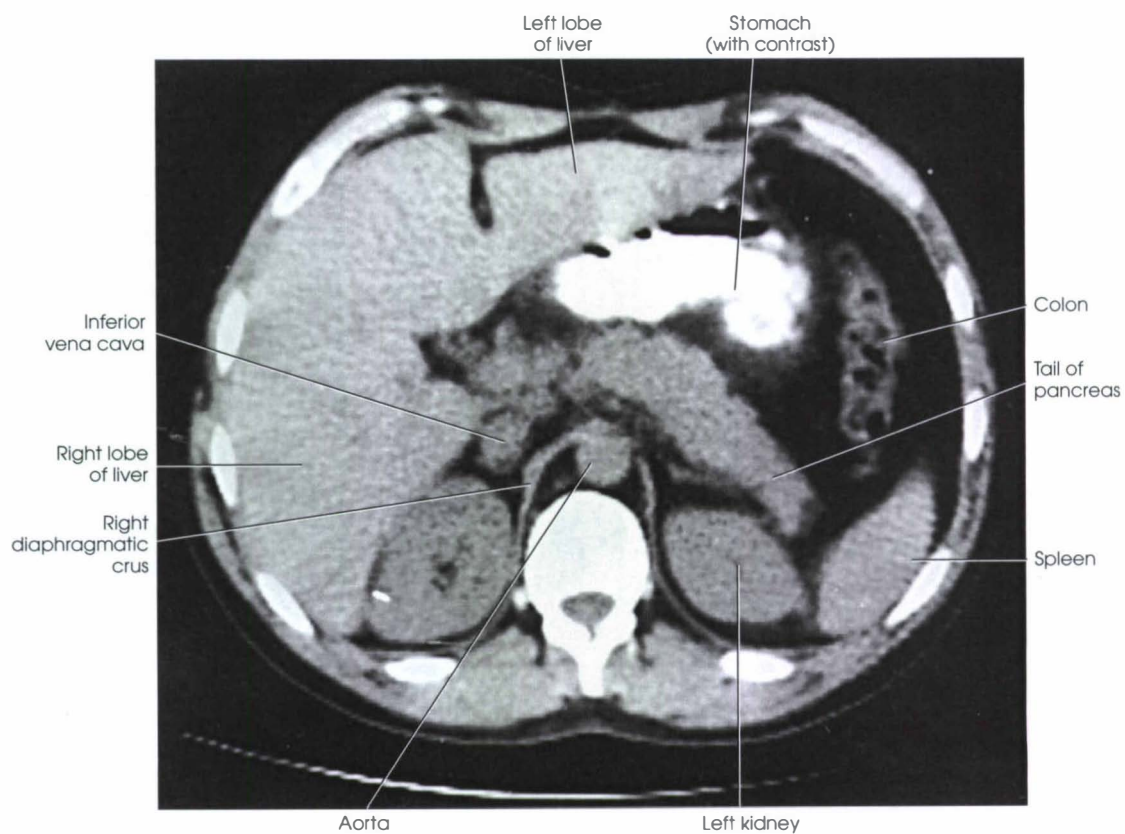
CT image corresponding to Fig. 27-32. Note the crus (tendinous origin) of the diaphragm surrounding the aorta.
